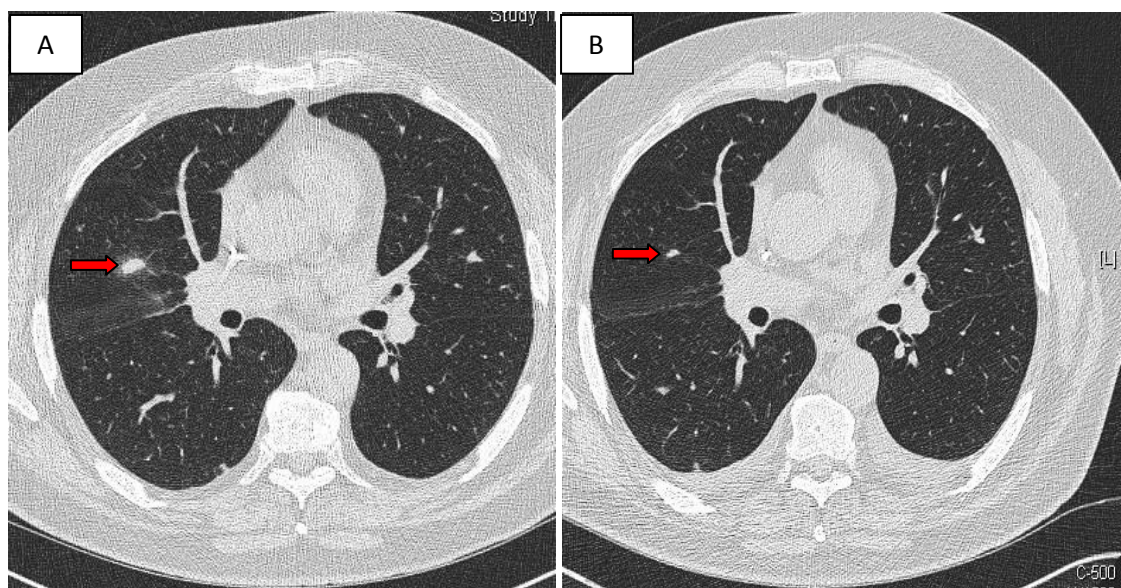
CT scan of JW 55y male with CML with normal neutrophil counts previously only treated with imatinib and dasatinib. He became febrile within 24-48h of starting conditioning chemotherapy. Baseline CT (A) showed nodules with halo sign (arrow). He was treated with Ambisome for 1 day and then changed to caspofungin
